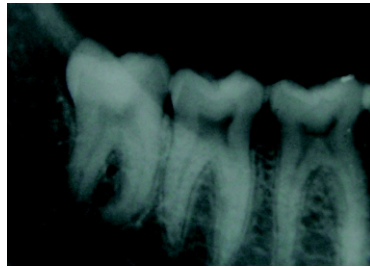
Pre operative radiograph of control (non graft) site
